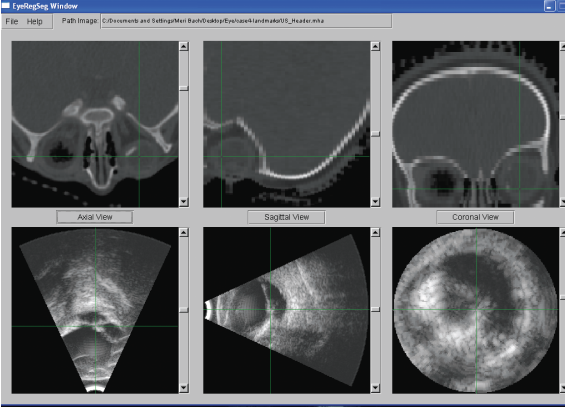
Data set: top row, 3D CT image of the head used for the treatment planning; bottom row, 3D ultrasound of the eye. Note that the green cross does not represent same spatial location.
